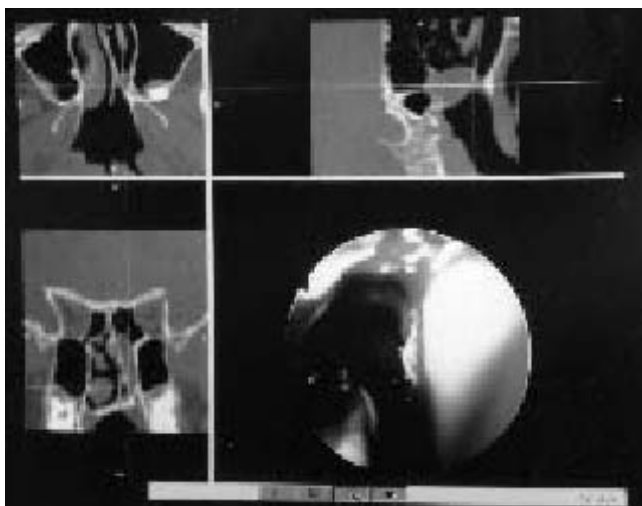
Perforation and cut of the bony plate with the guided microdebrider. The position of the microdebrider is visible on the CT layer (line going to the crosshair) and on the endoscopic view with the opening of the bony plate. On the coronal view of the CT is shown the asymmetry of the palate, the septum deformation and the absence of a normal inferior and middle turbinate on the left side [case 2].
